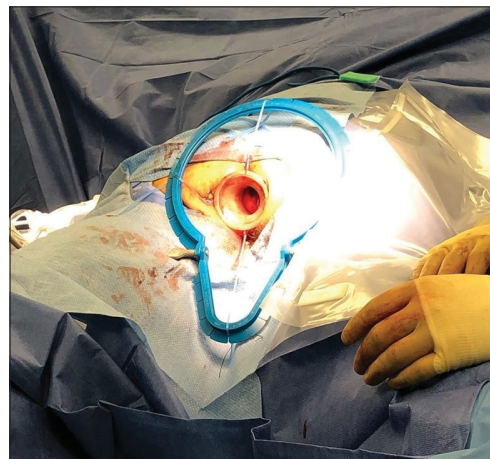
A Lone Star retractor® (Cooper Surgical, Trumbull, CT, USA) with GelPOINT® sleeve sutured to the skin
